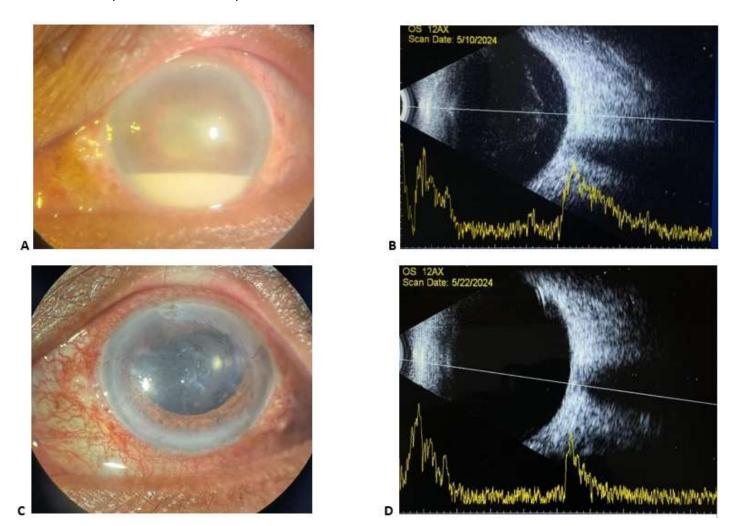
A case of acute postoperative endophthalmitis occurred in the left eye of the 68-year-old male, presenting nine days after phacoemulsification surgery. A. At the initial outpatient visit, anterior segment of the patient revealed dense corneal edema, hypopyon, and a secluded pupil. B. B-scan ultrasonography on the first day demonstrated low- to medium- reflectivity vitreous opacities, indicated the vitritis. C. Anterior segment 7 days following intravitreal antibiotic injection and pars plana vitrectomy showed a clear cornea, with no evidence of hypopyon or membranous formation. D. Ultrasonography on postoperative day seven showed absence of vitritis and an attached retina
